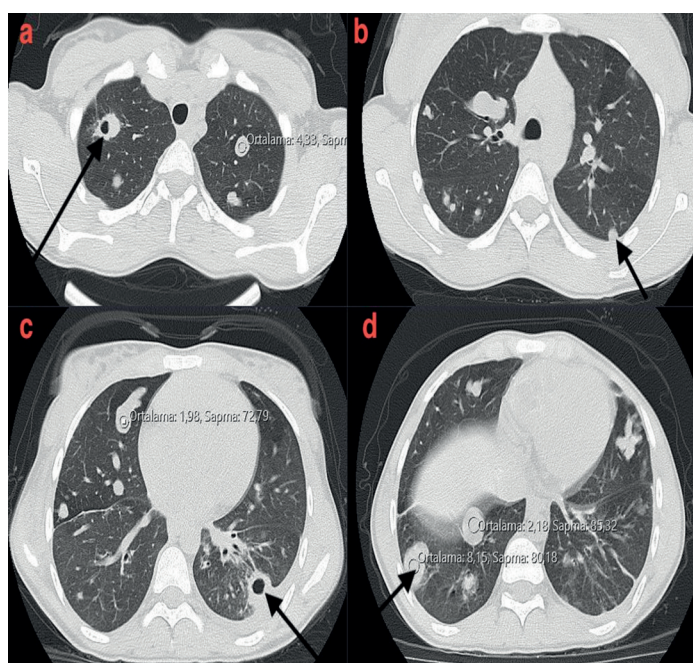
Unenhanced thorax CT
